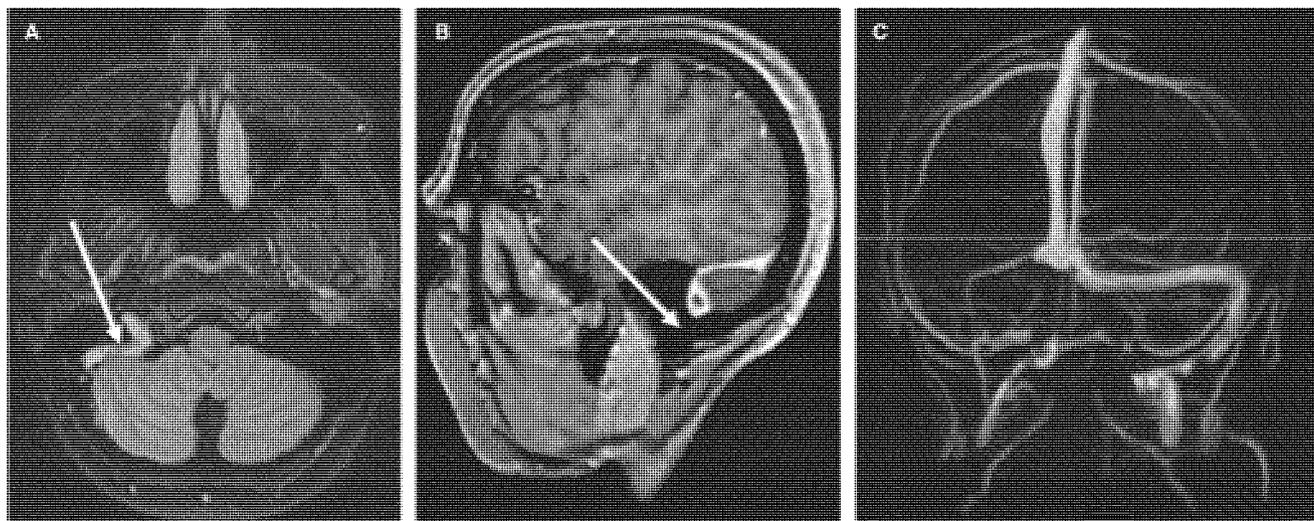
Cerebral sinus vein thrombosis on magnetic resonance imaging (MRI) sequences. (A) Fluid attenuated inversion recovery axial sequence showing absence of flow-void in the right sigmoid sinus (arrow). (B) Sagittal contrast enhanced T1-weighted sequence showing a partial occlusion of the right sigmoid sinus (arrow). (C) Three-dimensional reconstruction of the cerebral venous system showing the absence of flow in the right transverse and sigmoid sinuses and right internal jugular vein.
